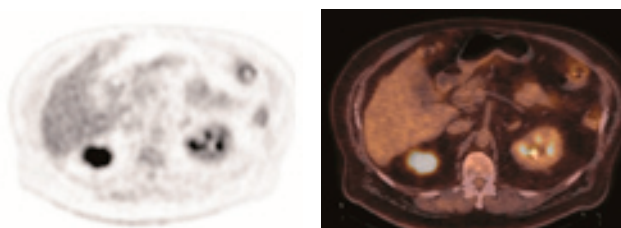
A 68 year old man with DLBCL and secondary involvement of kidney by lymphoma. Axial ^{18}F -FDG-PET (A) and fused PET/CT (B) images show 4.1cm ^{18}F -FDG avid mass in upper pole of right kidney with SUVmax 7.7, SUVmean 4.7, partial volume corrected SUVmean of 7.5, LBRliver 2.2, and LBRkidney 2.6.
